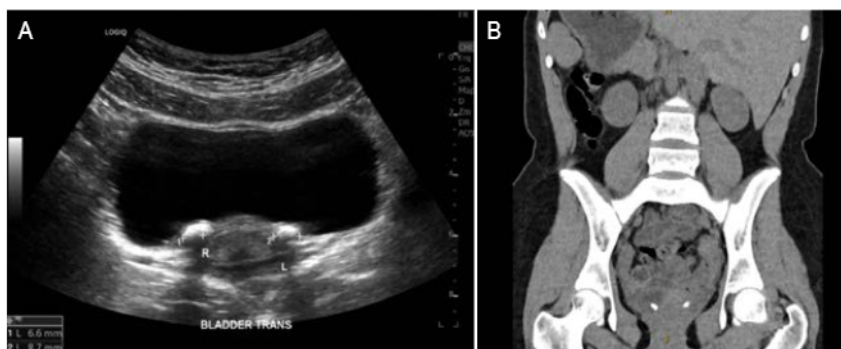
A – renal ultrasound identified bilateral bladder base calcification before urological referral for irritative bladder symptoms, B – consequent computed tomography scan showing the same bilateral bladder base calcification
